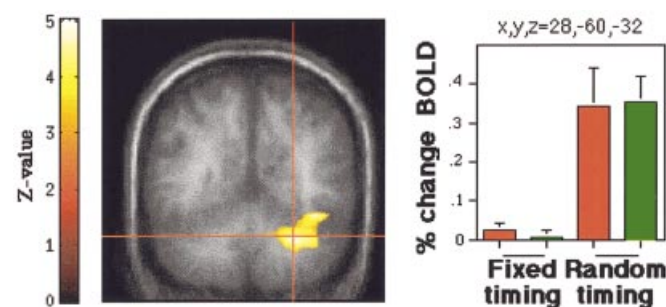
(Top) Main effect of timing irregularity superimposed on the mean structural MRI slices averaged across subjects. The Z-values for the regional maxima are listed in Table 1. (Bottom) Percentage of signal change relative to baseline for each task-switching condition in the right cerebellar hemisphere. Error bars indicate SEM.
